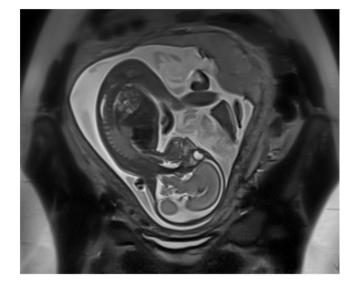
In utero fetal MRI. A T2-weighted MRI of a 20 weeks gestation fetus, scanned at 1.5 tesla is demonstrated. A coronal plane through the mother's abdomen shows the full gravid uterus, placenta and surrounding maternal structures. This plane also provides a parasagittal view through the fetus, clearly visualizing the midbrain, fourth ventricle and cerebellum. Image on courtesy of the Department of Radiology and Nuclear Medicine of the Amsterdam UMC, dr. N. Ahmadi.
